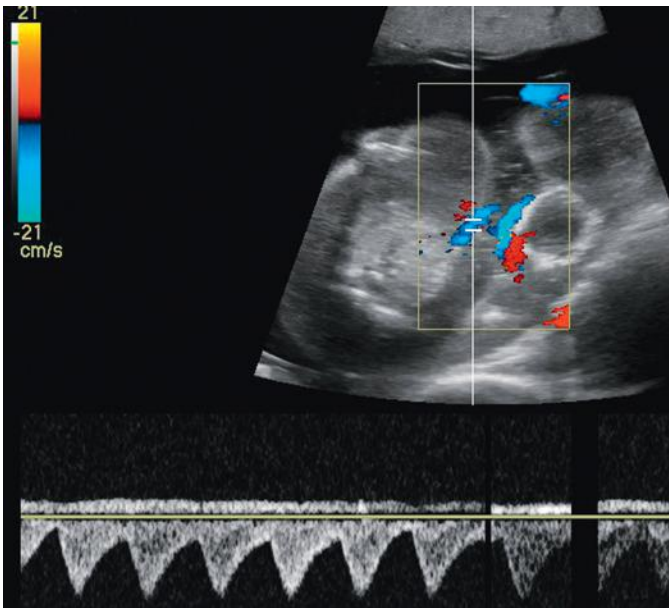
Twin reversed arterial perfusion (TRAP) sequence. Transaxial ultrasound image of the acardiac twin at the level of the umbilical cord insertion. Color and spectral Doppler interrogation demonstrates reversed pulsatile arterial flow (in blue), directed away from the transducer toward the acardiac fetus. This Doppler ultrasound finding is pathognomonic of TRAP sequence.
